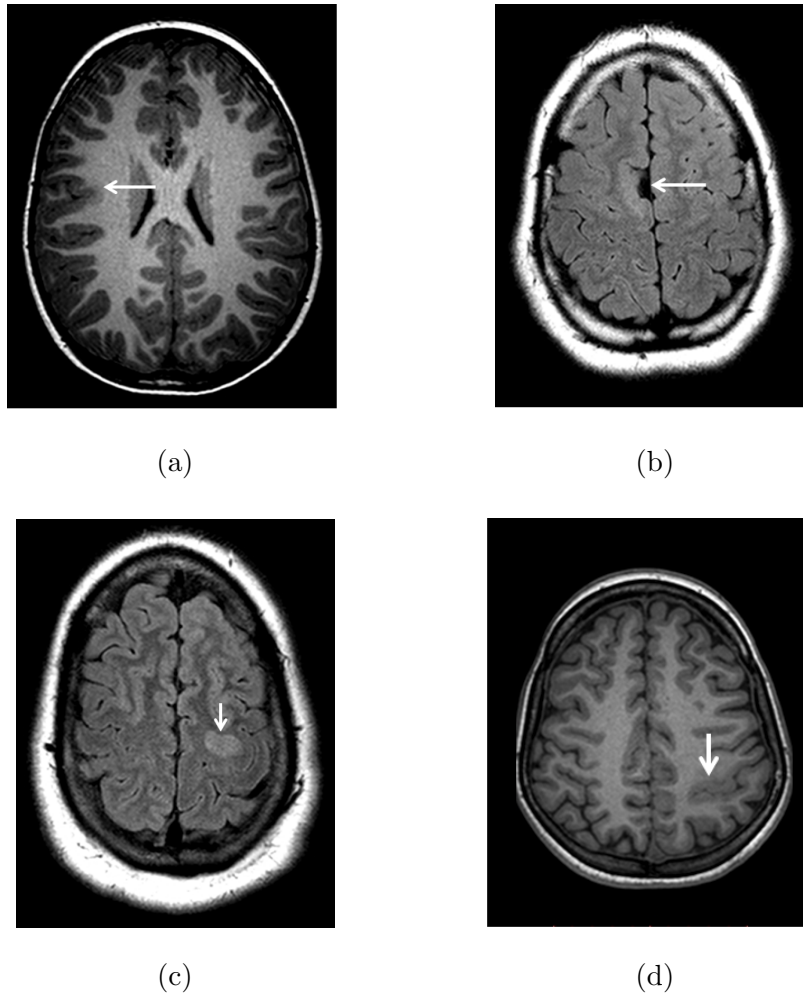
MRI features of FCD used in standard neuroradiological analysis. Recognized FCD features include blurring of the gray-white matter junction, abnormal signal in the white or gray matter, abnormal sulcal pattern, and cortical thickening. Sample cases with arrows indicating regions of abnormality on the basis of standard MRI features used for diagnostic analysis. (a) Blurring Gray White Junction and also high T1 signal in cortex (Subject NL005), (b) Abnormal Sulcation (Subject NL036), (c) High signal in cortex (FLAIR) (Subject NL037) and (d) Abnormal Cortical Thickness (Subject NL039). Two cases of high signal are presented in (a) and (c). The reason for doing so is to depict that even in cases where the same feature is present, the magnitude at which it presents itself may vary from subject to subject.
